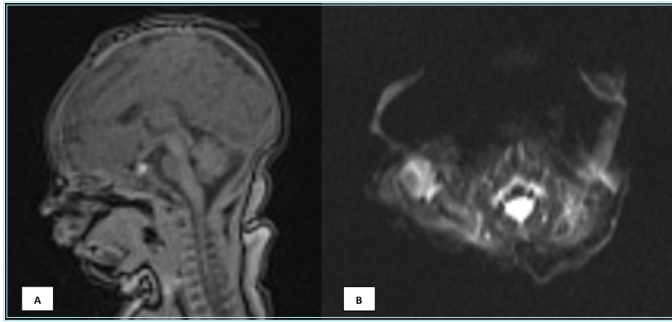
(A, B) MRI images in a newborn male child showed movement artifacts
